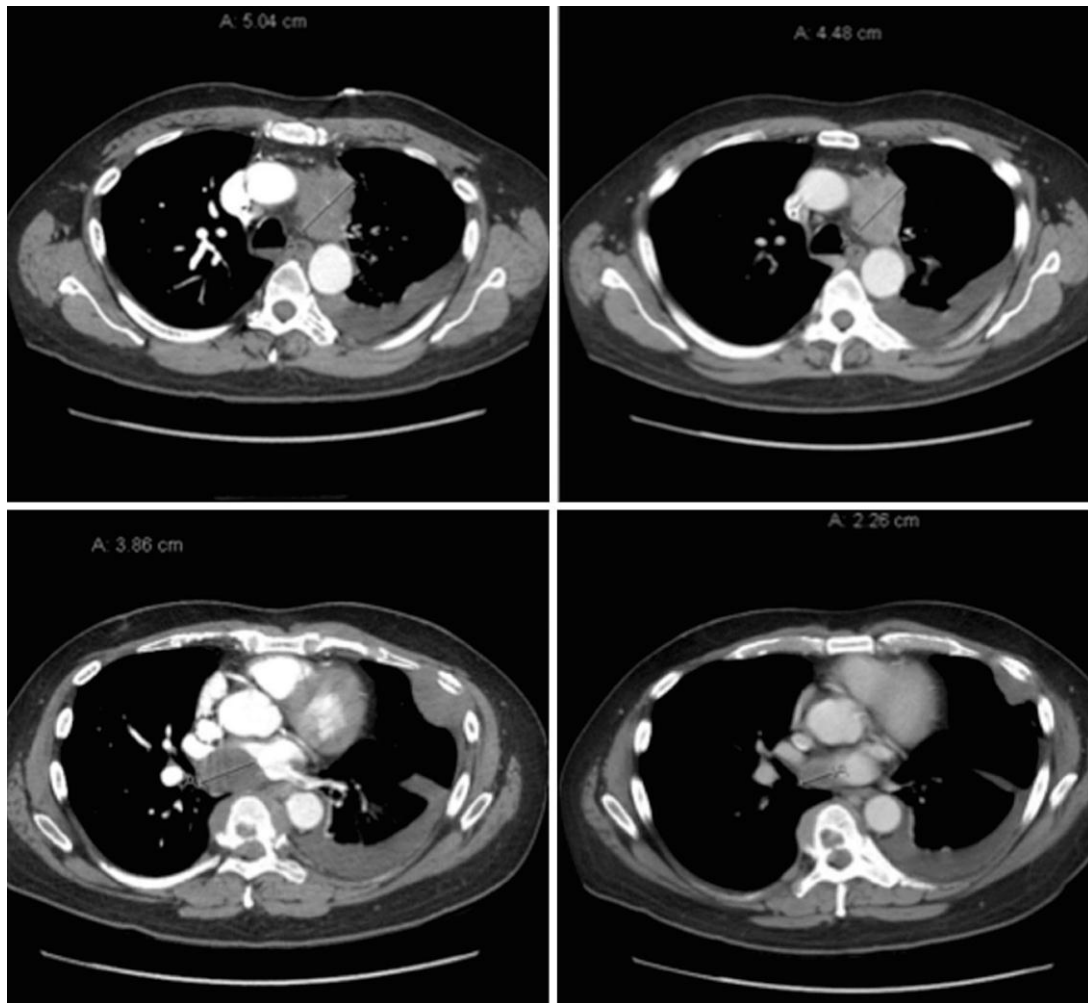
CT scans of the lungs demonstrating a significant reduction of target lesions (approximately 32% compared to baseline) 6 weeks after reintroduction of etoposide and cisplatin. Left: tumor scans after RRx-001. Right: tumor scans after etoposide and cisplatin treatment.
